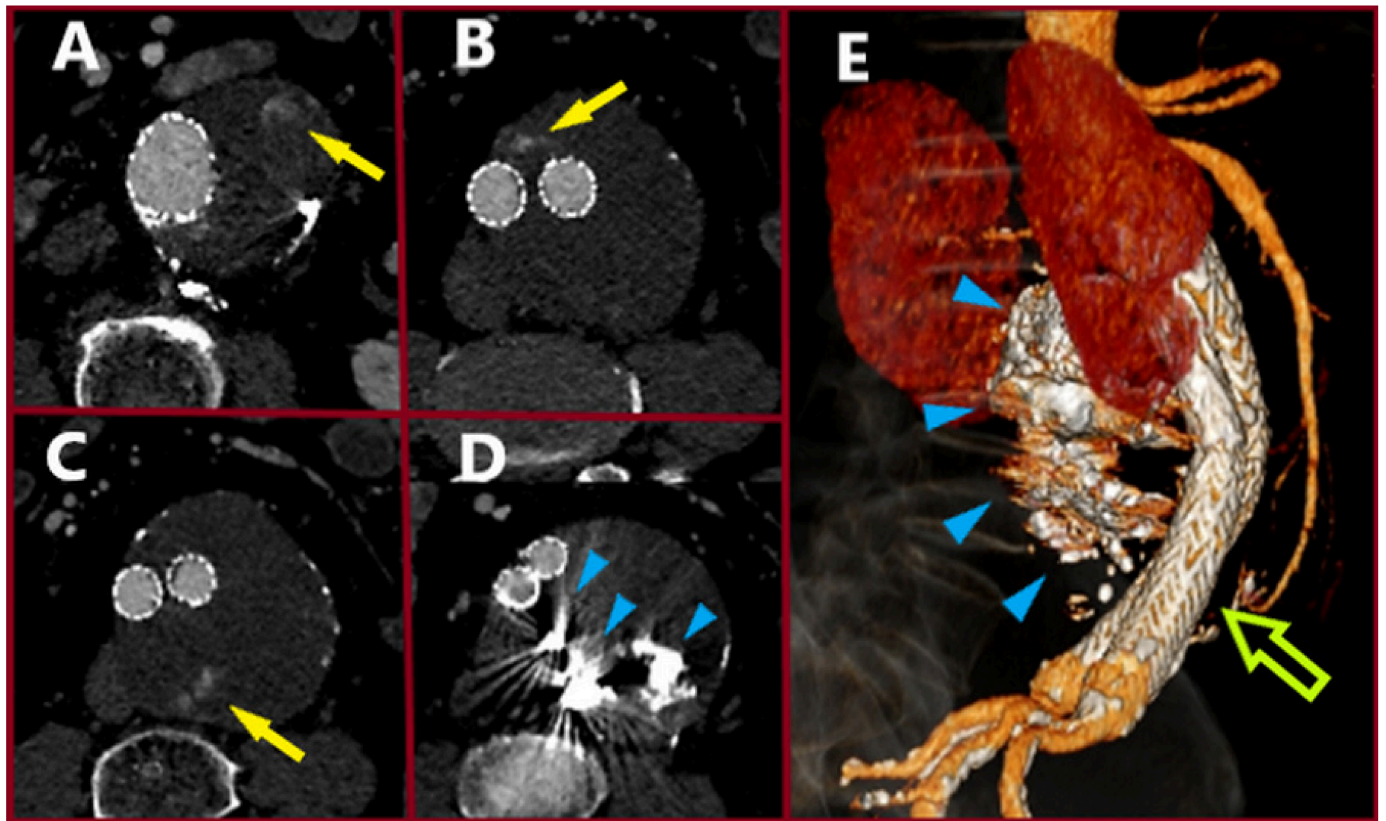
Preoperative Computed Tomography Angiography (CTA). (A–C) Contrast pooling in the aneurysmal sac due to atypical T2EL in axial images. No clear connection with a feeding branch is detected. Implication of a hypertrophied and developed vasa-vasorum network is considered. (D) Onyx embolic material in the aneurysmal sac from previous embolization procedures (blue arrowheads). (E) 3D Reconstruction of a CTA depicting the endograft (green arrow) and the embolic material (blue arrowheads).
